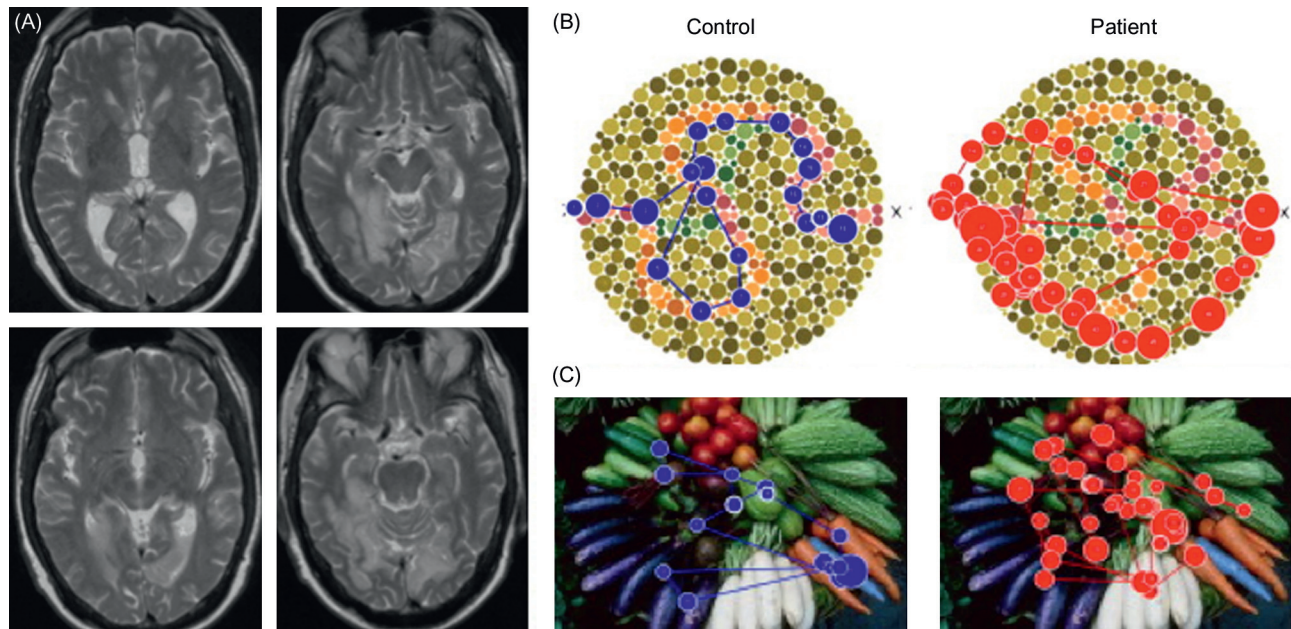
Cerebral achromatopsia with anosognosia. The patient could only see shades of grey but did not report impaired color perception (the deficit lasted less than 2 months). (A) Axial T2-weighted MRI scan slices of the patient showing bilateral hyperintense lesions in the occipito-temporal cortex 2 days after the stroke. (B) During an Ishihara task, the patient showed visual fixations that were unsystematically distributed while the control subject clearly followed the path. (C) Fixation density plots for an object-color matching task where subjects were instructed to search for any oddity in the image (here a blue carrot). The patient did not notice anything in particular. *Source: Adapted from von Arx et al. (2010).*
